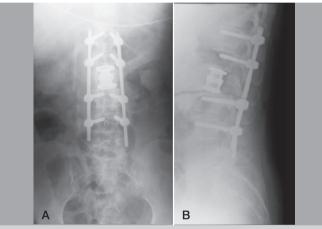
Postsurgical x-ray's.
